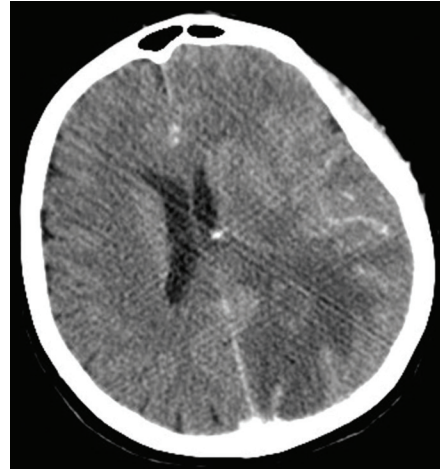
Axial brain CT with contrast demonstrates a poorly defined area of the left parietal lobe, with surrounding edema, and ring-like enhancement.
